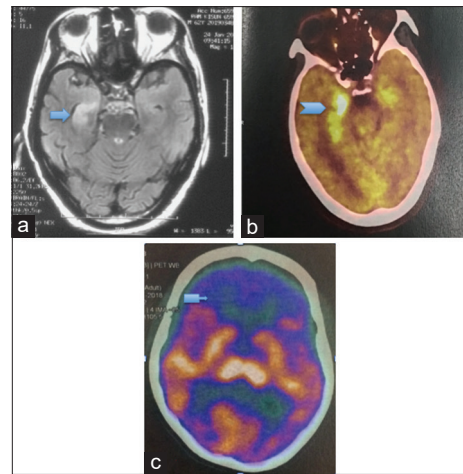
T2 Flair right medial temporal lobe hyper intensity (arrow in Figure a) in MRI brain and right medial temporal lobe hyper metabolism (notched arrow in Figure b) in PET scan of a CASPR2 antibody positive AE patient. Frontal hypo metabolism (arrow callout in Figure c) in PET scan of a NMDAR antibody positive AE patient
